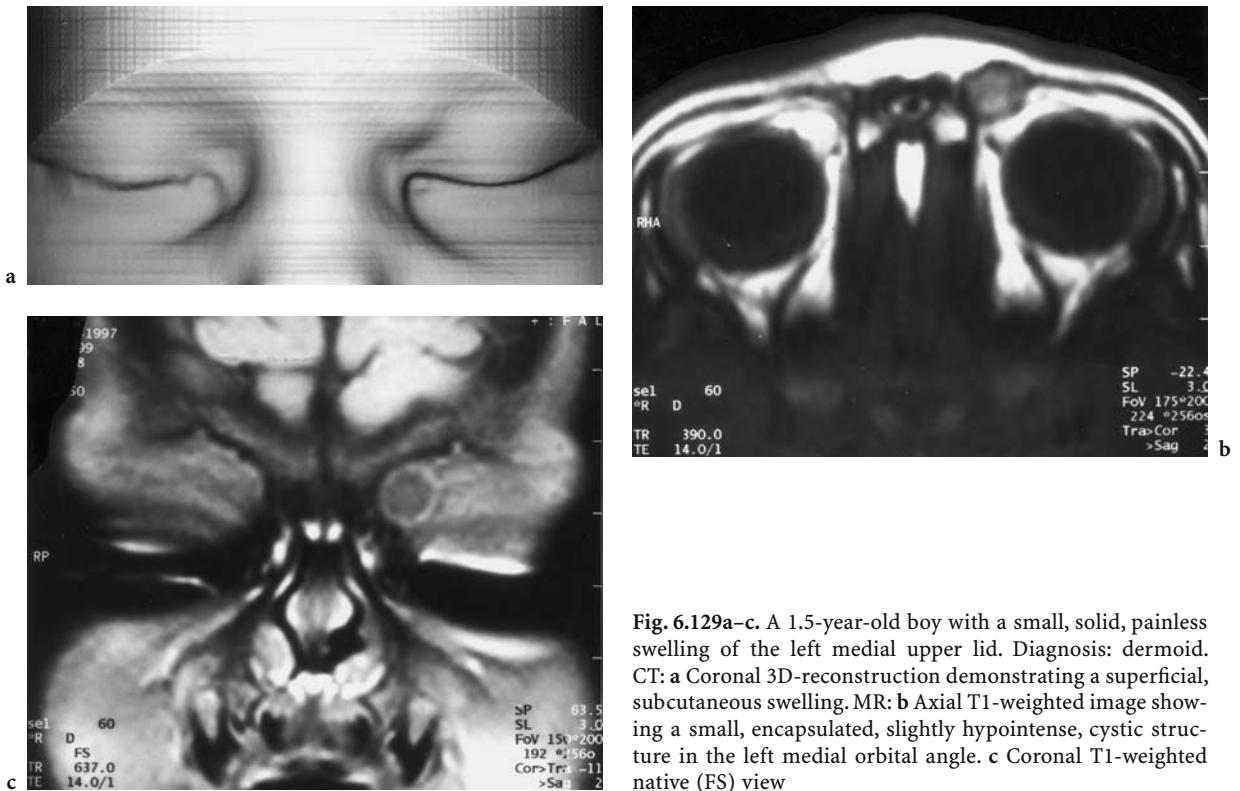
A 1.5-year-old boy with a small, solid, painless swelling of the left medial upper lid. Diagnosis: dermoid. CT: a Coronal 3D-reconstruction demonstrating a superficial, subcutaneous swelling. MR: b Axial T1-weighted image showing a small, encapsulated, slightly hypointense, cystic structure in the left medial orbital angle. c Coronal T1-weighted native (FS) view
